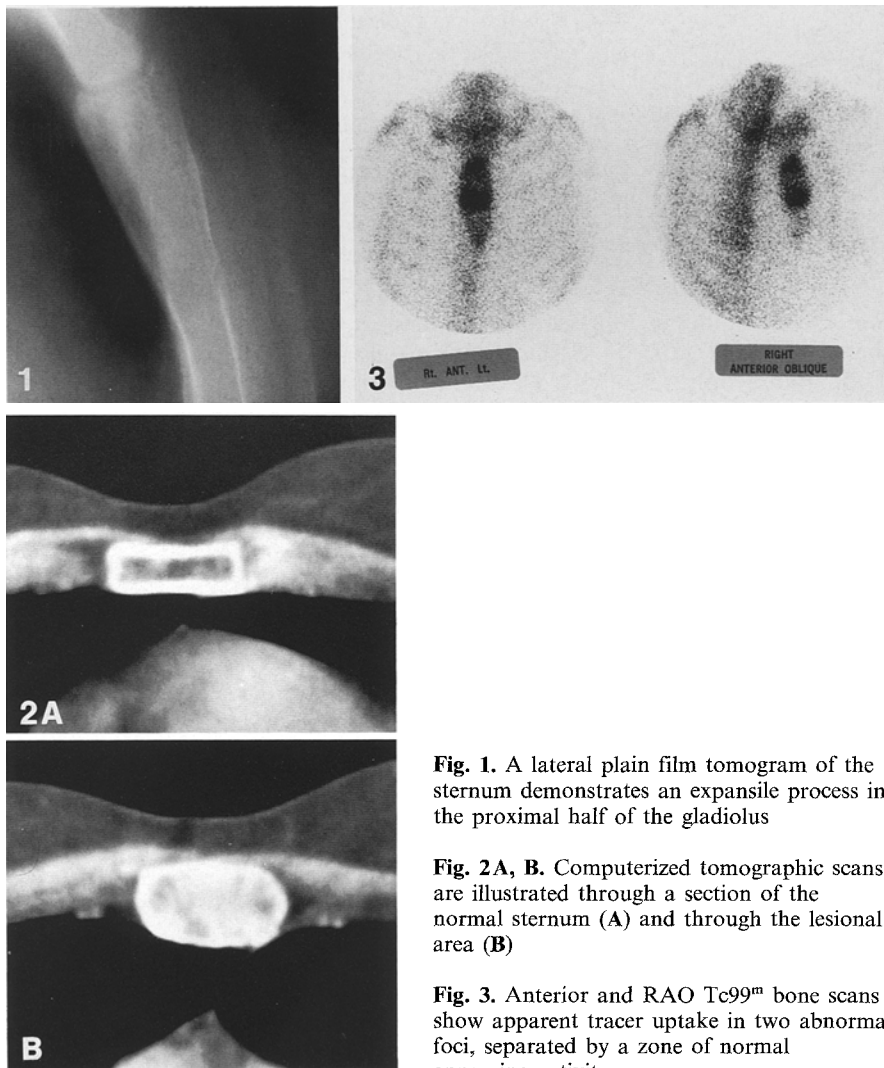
A lateral plain film tomogram of the sternum demonstrates an expansile process in the proximal half of the gladiolus
